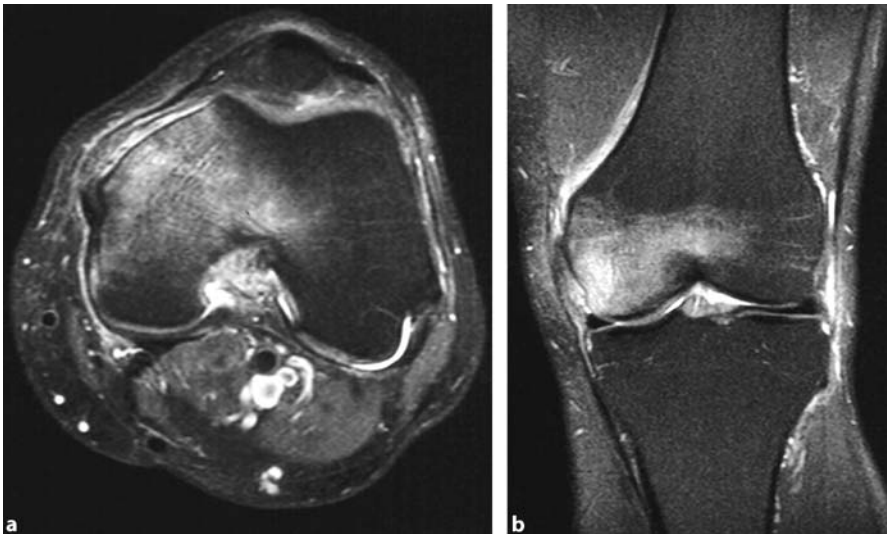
Massive and widespread non-traumatic BME of the medial femur condylus, T2-weighted, fat saturated sequence images in a 54 year old male patient, with severe pain
